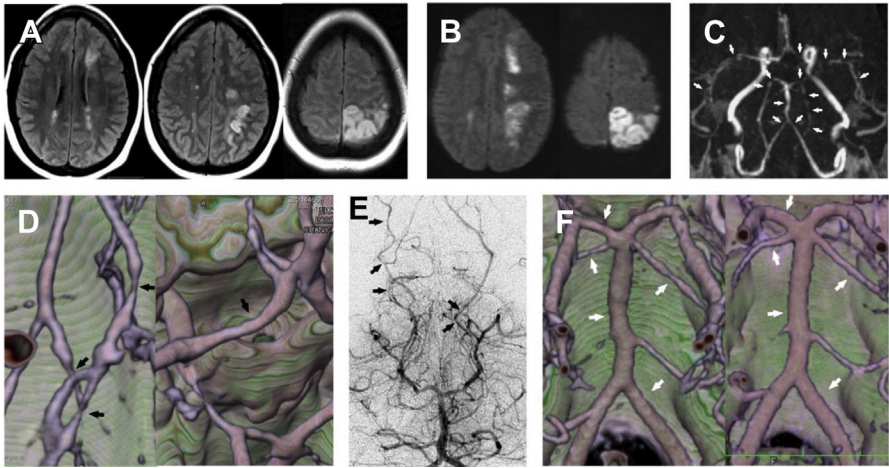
RCVS. (A) MRI FLAIR imaging on presentation demonstrates multifocal abnormal hyperintense signal within the bilateral hemispheric white matter, more prominent in the parietal and occipital lobes where it extends to the cortex. (B) T_2 -diffusion imaging demonstrates restricted diffusion consistent with acute ischemia. The white matter distribution within the left hemisphere straddles the anterior, middle, and posterior cerebral vascular territories, a “watershed” distribution. (C) MRA at admission demonstrates short-segment multifocal narrowing within the distal bilateral vertebral arteries, the basilar artery, and bilateral middle and posterior cerebral vasculature (*white arrows*). (D) CTA demonstrates moderate narrowing within the right PCA P2 segment and a more severe narrowing distally within the P3 parieto-occipital segment (*left, black arrows*). Mild narrowing is present within the ACA A1 segment (*right, black arrow*). (E) CA confirms multifocal narrowing within the bilateral posterior cerebral arteries (*black arrows*). (F) Follow-up CTA (at presentation on the left, 5 months’ follow-up on the right) reveals complete resolution of the original findings (*white arrows*). (Courtesy of Adam Davis, MD New York, NY.)
